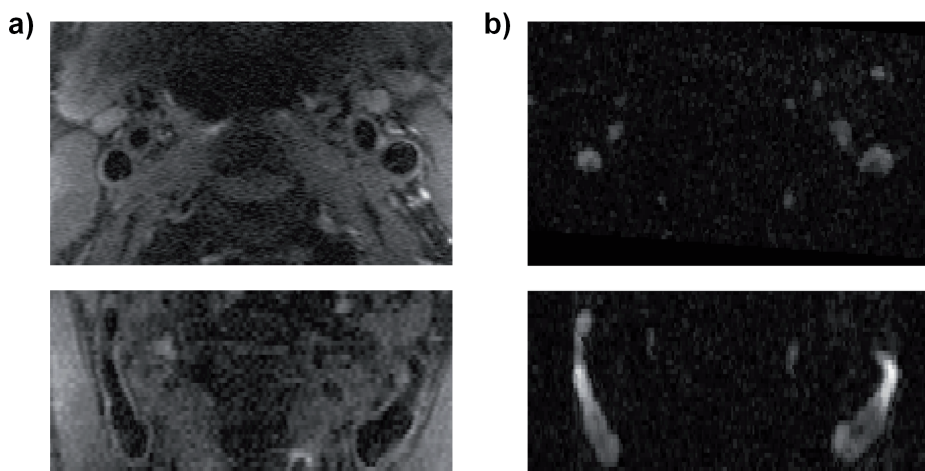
Typical a) PDw-EPI b) 3D time-averaged PC MRI complex difference images in axial (top) and coronal (bottom) view
